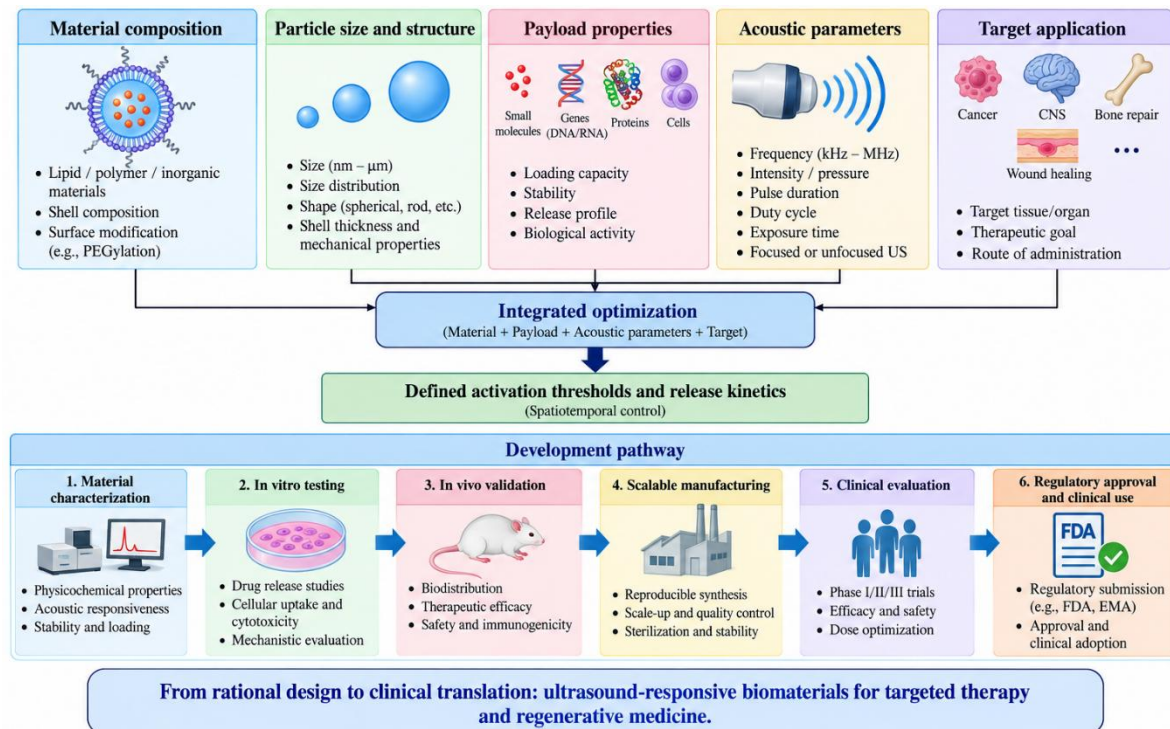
Design roadmap for ultrasound-responsive biomaterials.
